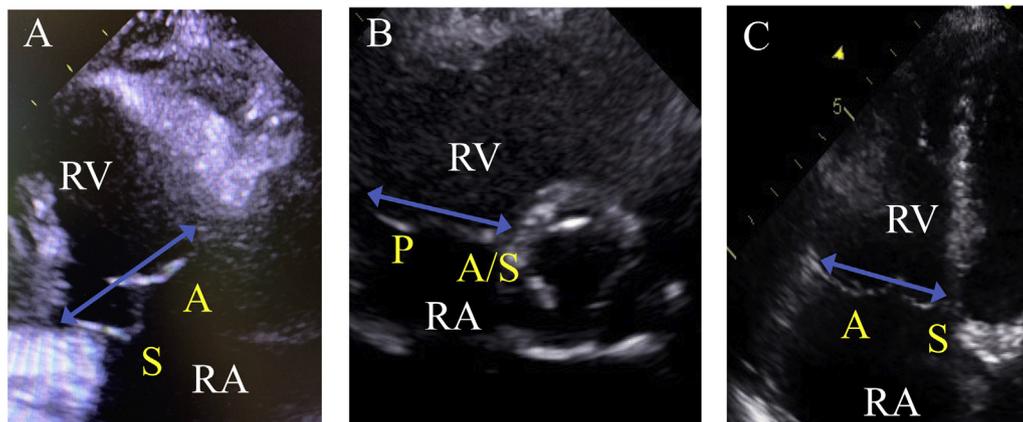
Sample transthoracic echocardiographic images demonstrating location of the tricuspid annular plane in multiple views. Transthoracic echocardiographic views of individuals with TVP demonstrating the location of the tricuspid annular plane (blue double-headed arrow) in the RVI view (A), the PSAX view at the level of the aortic valve (B), and the 4CH view (C). Yellow letters indicate the respective tricuspid valve leaflets identified. A, Anterior; A/S, anterior or septal; P, posterior; RA, right atrium; RV, right ventricle; S, septal.
